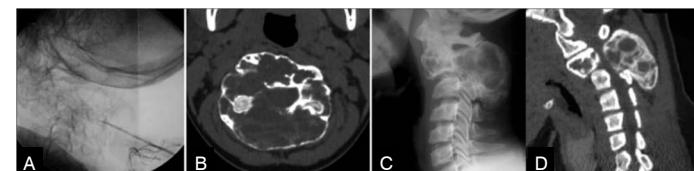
(Case 3) (A) Plain film of the cervical spine showing the needle inside the lesion that is involving the posterior arch of C2. (B) The CT scan demonstrates the expansive lytic lesion involving the body and posterior arch of C2, which presents fluid-fluid levels. The plain film (C) and sagittal CT scan (D) performed one year later show the shrinkage of the lesion and the ossification of its walls. Notice the reduction of size of the cavities.
